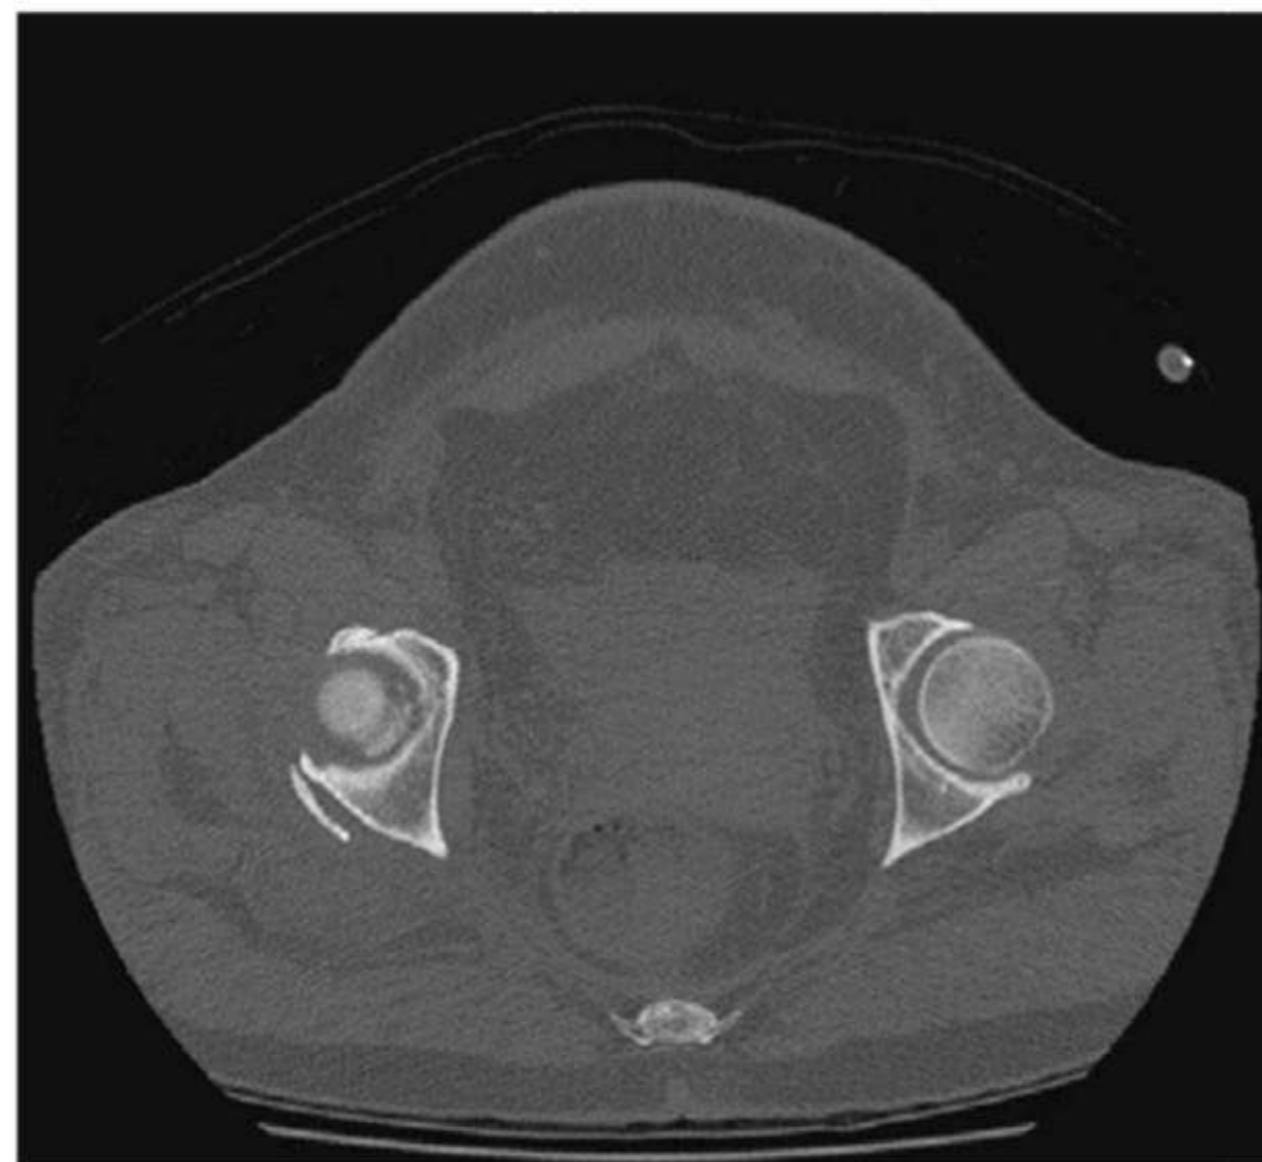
CT axial view pelvis.
